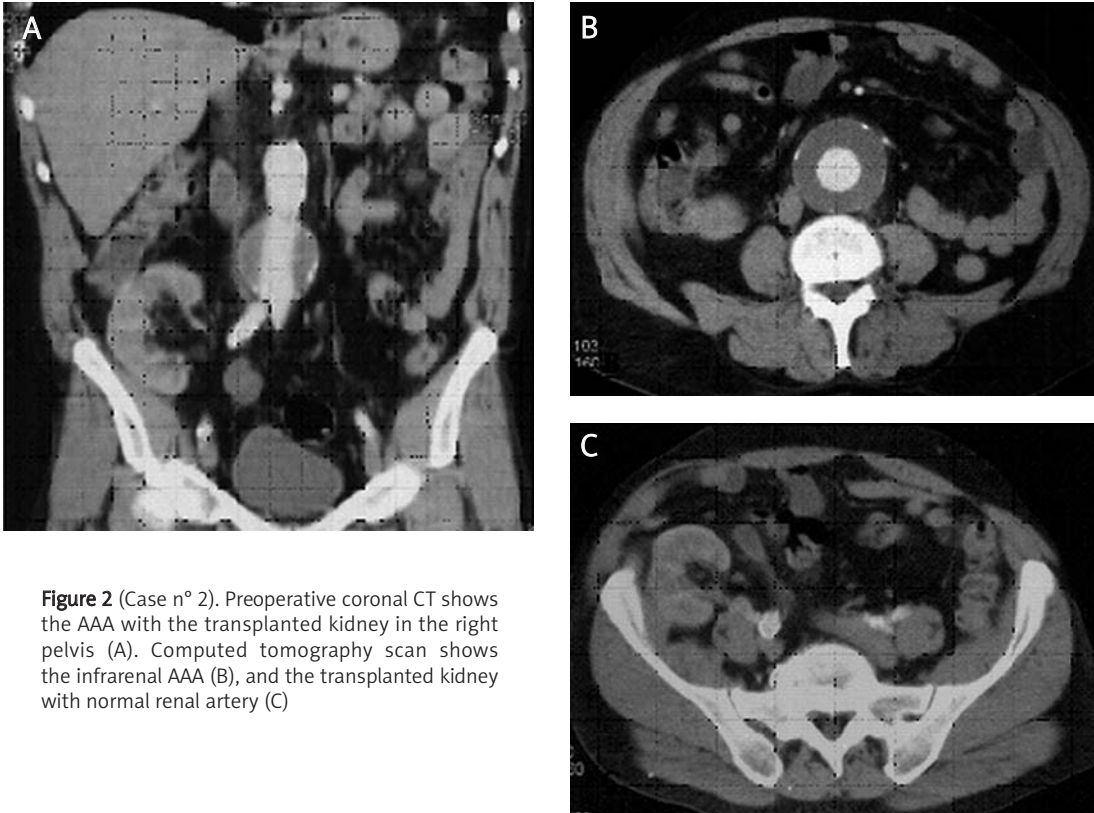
(Case n° 2). Preoperative coronal CT shows the AAA with the transplanted kidney in the right pelvis (A). Computed tomography scan shows the infrarenal AAA (B), and the transplanted kidney with normal renal artery (C)
